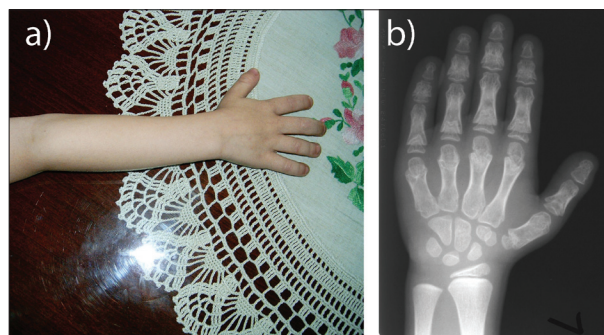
Brachydactyly in Jeune syndrome: a) typical broad hand with short fingers of the patient JATD 8; b) X-ray of the left hand of the same patient; note short and dysplastic phalanges
